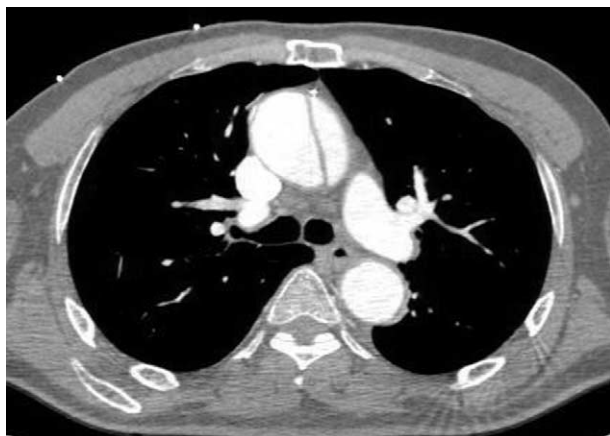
CTA of chest showing dissection of ascending aorta with normal descending aorta.
